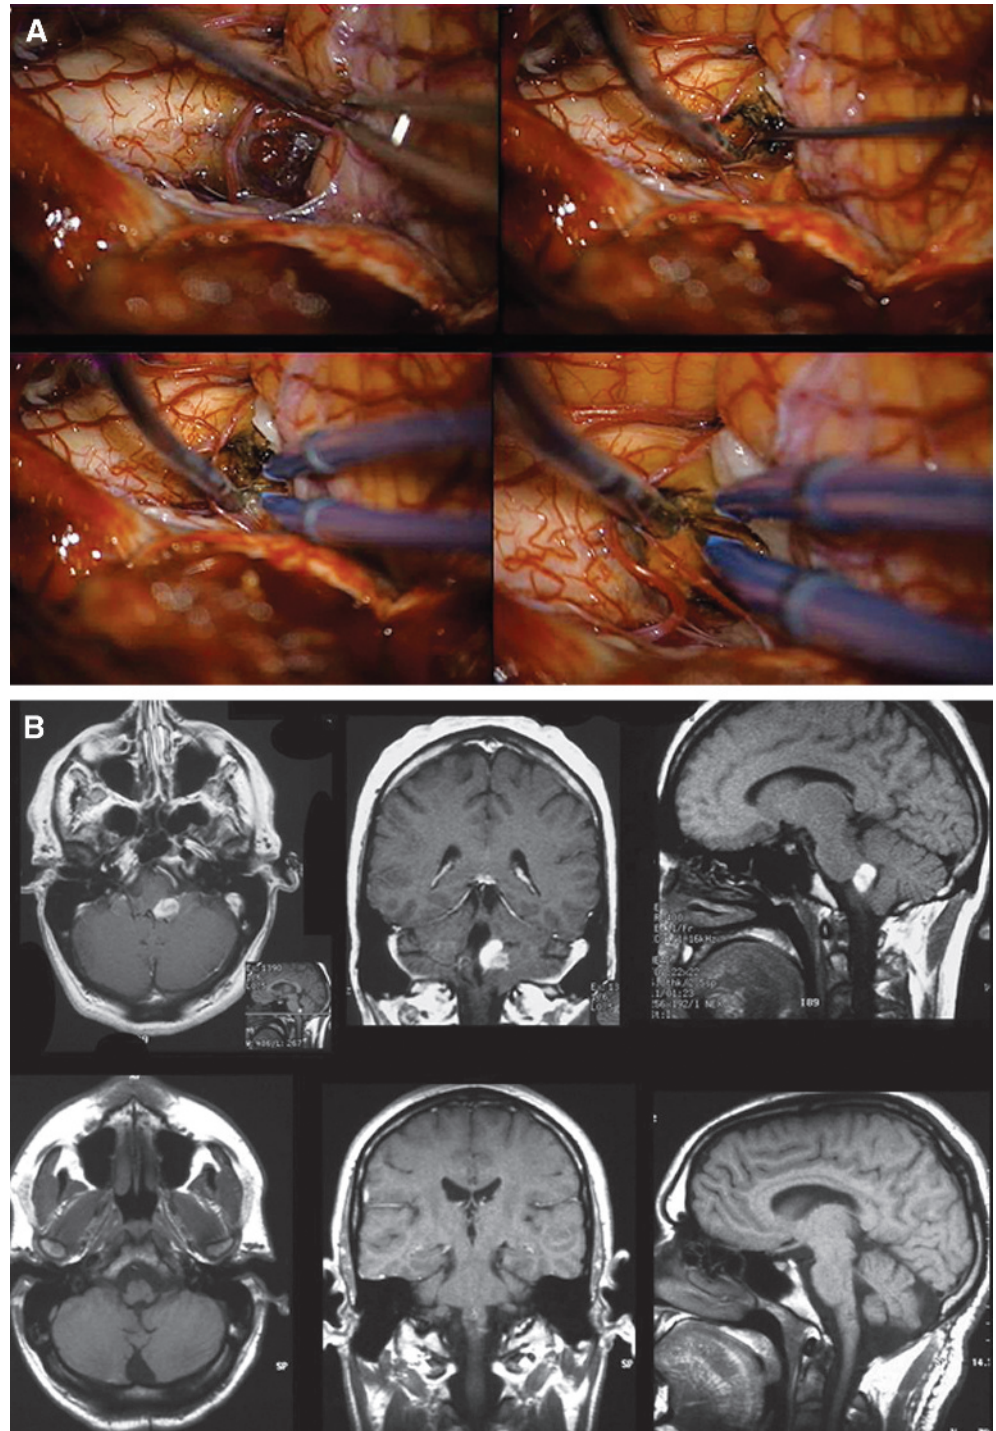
A, transcondylar approach. Top left, exposure of the ventrolateral cavernous malformation of the medulla beneath the right cerebellar tonsil. Top right, circumferential dissection of the malformation from the surrounding brainstem. Bottom, piecemeal resection of the malformation. B, top, preoperative MRI of the cavernous malformation shown above. Bottom, postoperative MRI documenting complete resection of the malformation.
